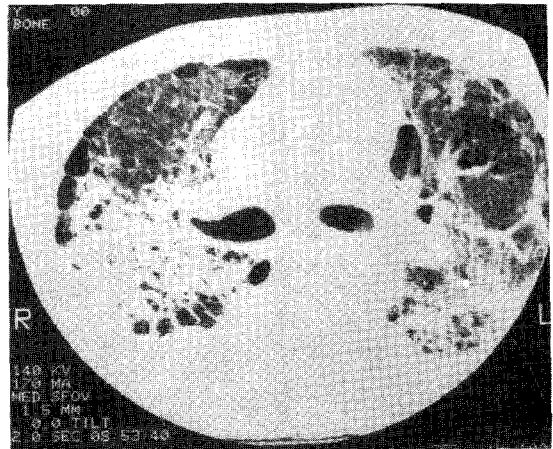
High Resolution CT: diffuse increase of interstitial marking in whole lung field.
